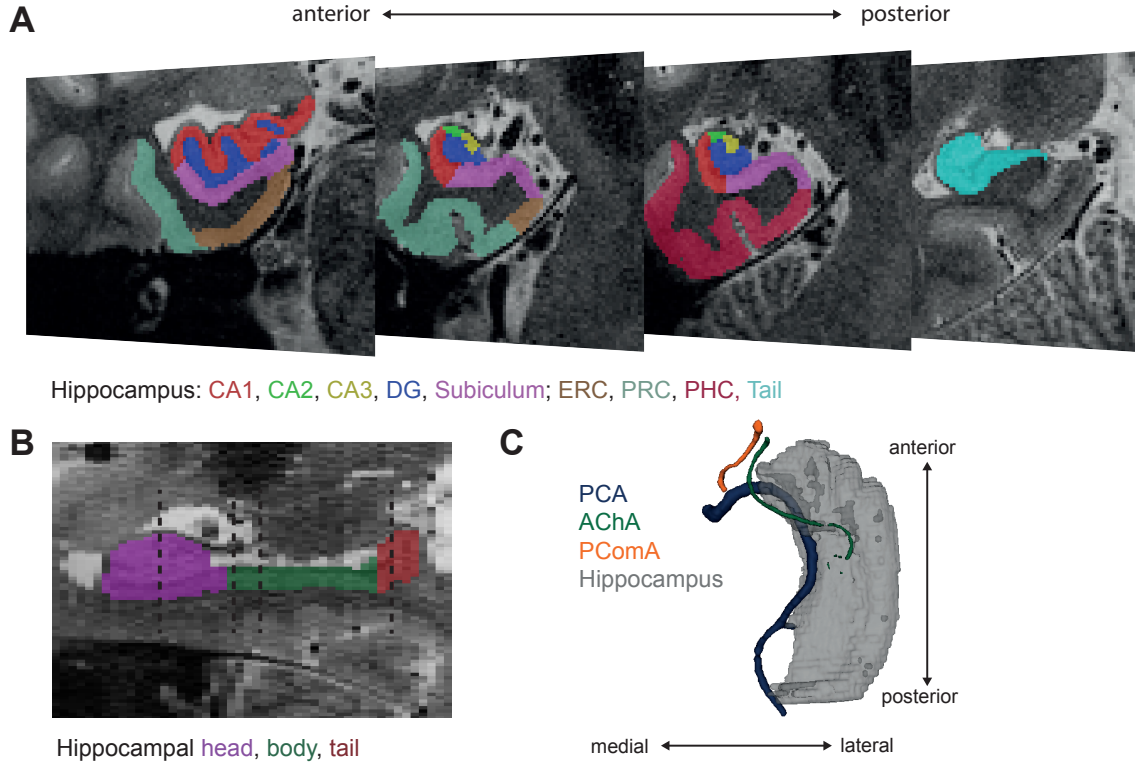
Medial temporal lobe. (A) Zoomed-in coronal view of the left MTL on four slices of a high-resolution T2-weighted MRI scan including MTL subregions and hippocampal subfields. (B) Zoomed-in sagittal view of the same hippocampus, divided into head, body and tail (other MTL subregions not shown). The dashed lines indicate the positions of the coronal slices shown in panel A. Please note that the orientation of the hippocampus within the brain is usually slightly tilted, but is displayed as straight, since MRI acquisition was parallel to the hippocampal long axis. (C) Roughly axial 3D view of the right hippocampus and the main trunks of its surrounding vessels segmented on a ToF MRA image (see section 1.4 for more information).
